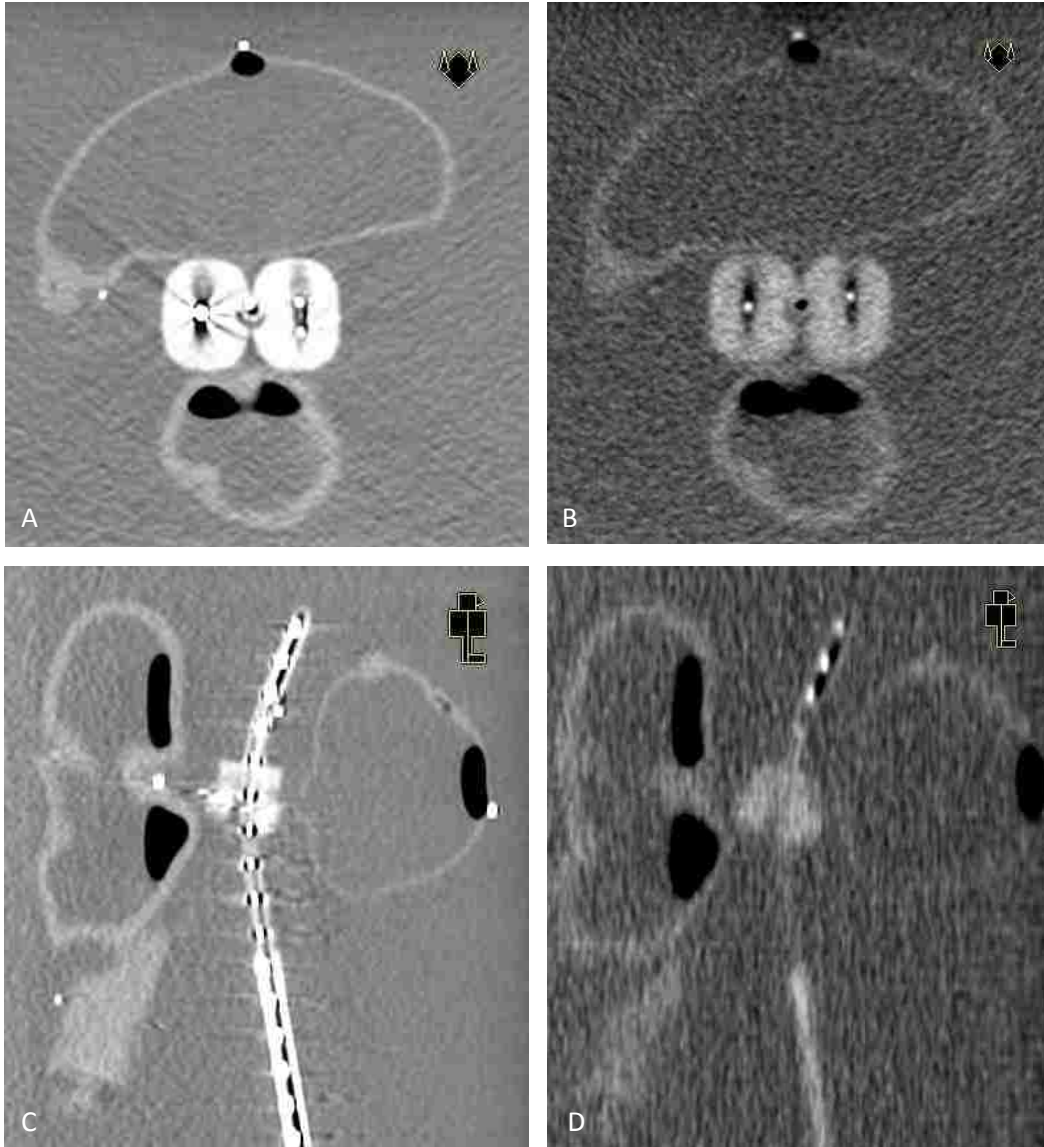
Corresponding axial and sagittal CT slices of kV and MV acquisitions for Nucletron's unshielded CT/MR compatible Fletcher applicator. Images (A) and (C) are the transverse and sagittal slices, respectively, acquired via kV imaging. Images (B) and (D) are the transverse and sagittal slices, respectively, acquired via MV imaging. Also, using fiducial markers, the same slice was chosen for both kV and MV images for both transverse and sagittal slices. Window and level values were 500 and 1, respectively.
